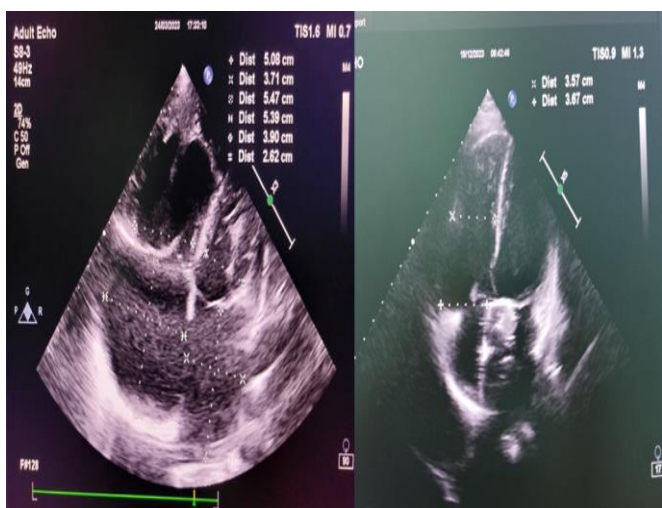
Echocardiography; Decreased RV Dilatation
